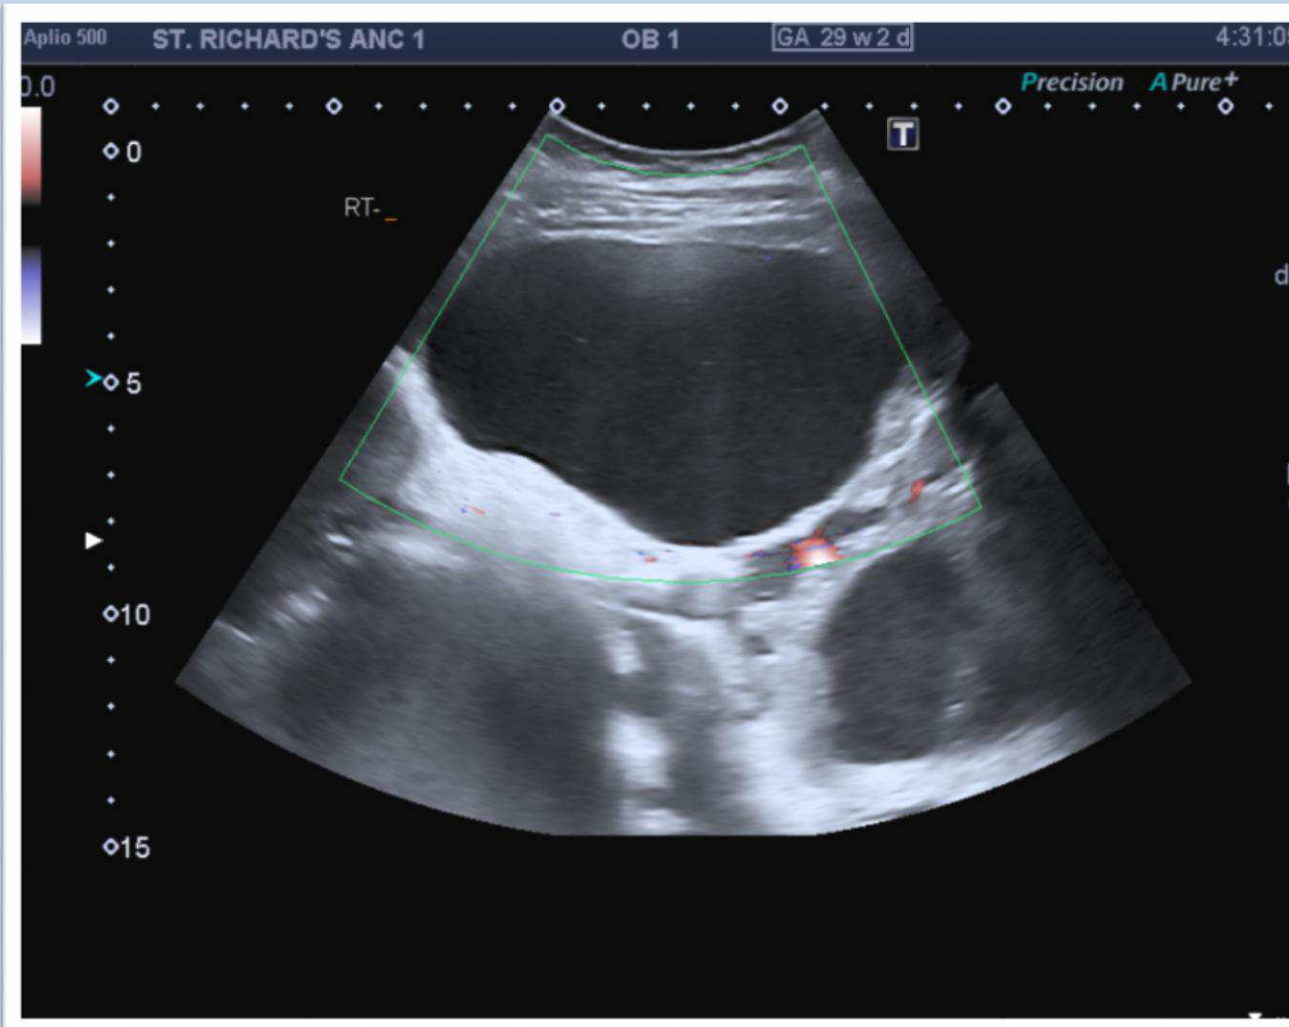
Sonography showing right simple ovarian cyst
